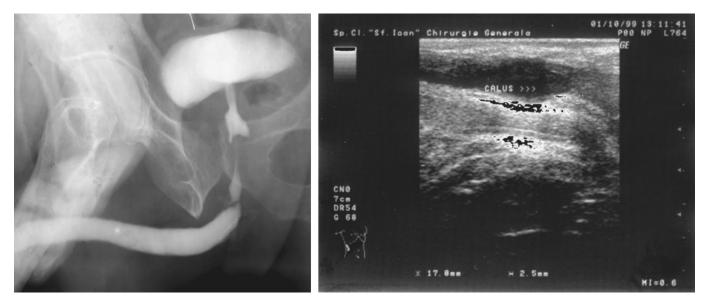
Stricture of the bulbar urethra, with spongiofibrosis seen by ultrasound at 6 and 12 o'clock.
